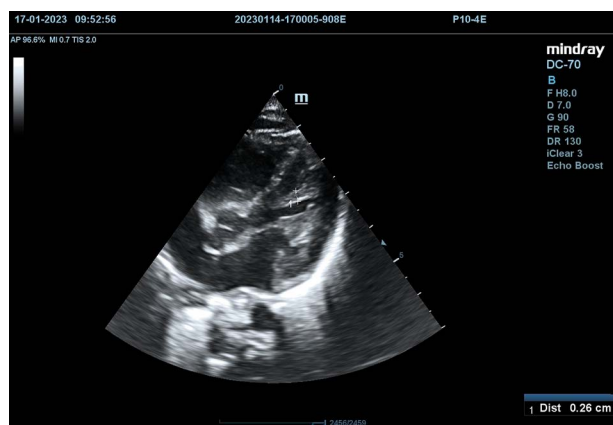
Echocardiography hyperechogenic a tendinous cord attached to the interventricular septum along the left ventricular outflow tract. Examination performed by MWM
